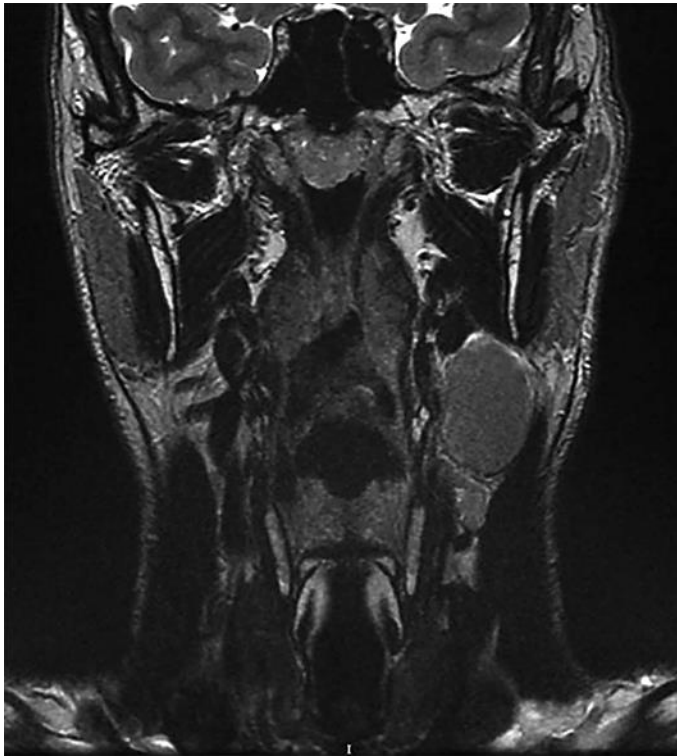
T2 FSE, coronal view, MRI of the neck, with and without paramagnetic contrast (Gd-DPTA), shows a lesion with an irregular border, located along the nasopharyngeal region, having a transverse diameter of about 13 mm and extending 15 mm with hyperintense signaling on T2-weighted imaging.
